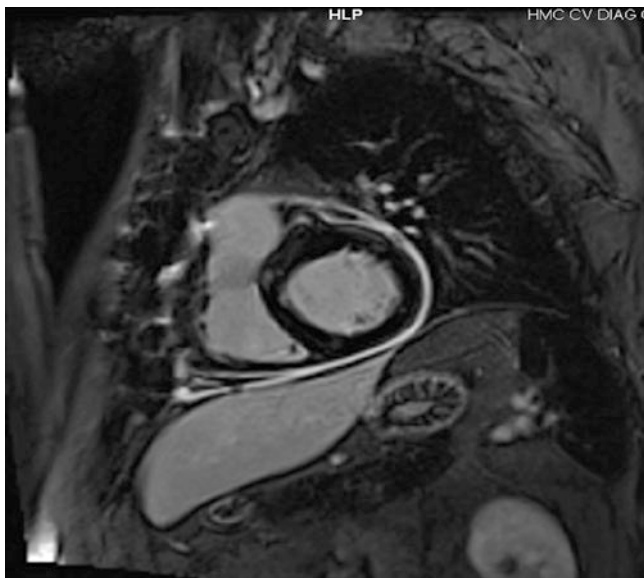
(a) Pericardial Effusion – Axial Black Blood MR image. White arrows point to black space surrounding the heart, which represents a pericardial effusion. (b) Pericardial Effusion – Four Chamber
